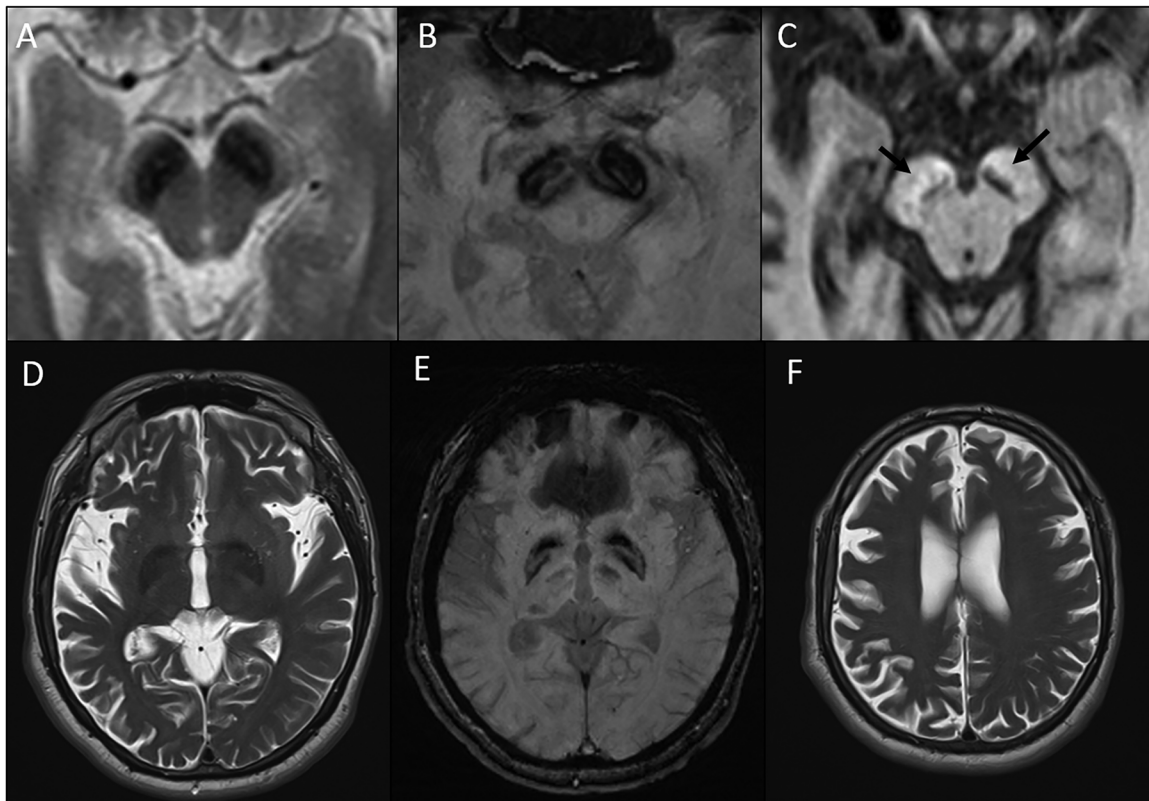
Brain MRI. Axial T2-weighted (W) turbo spin-echo images (a, d, f) and susceptibility-weighted images (b, e), T1-W MPRAGE (c) image. Substantia nigra and globus pallidum show T2 hypointensity and more prominent susceptibility on SWI (a, b and d, e). On T1W image, a hyperintense halo surrounds central hypointensity in the substantia nigra (black arrows, c). Please note that cerebral volume loss is more pronounced in the right hemisphere (d, f).
